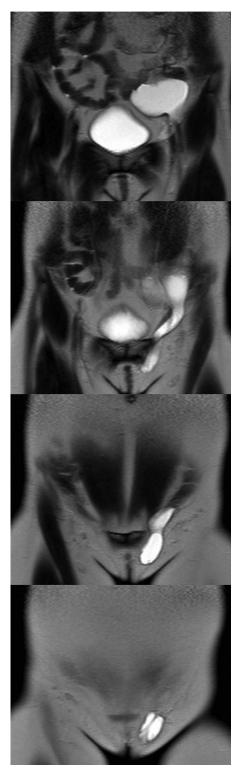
Magnetic resonance images of hydrocele of the canal of Nuck demonstrating a large intra-abdominal portion communicating through the inguinal canal with an external portion in the groin.
